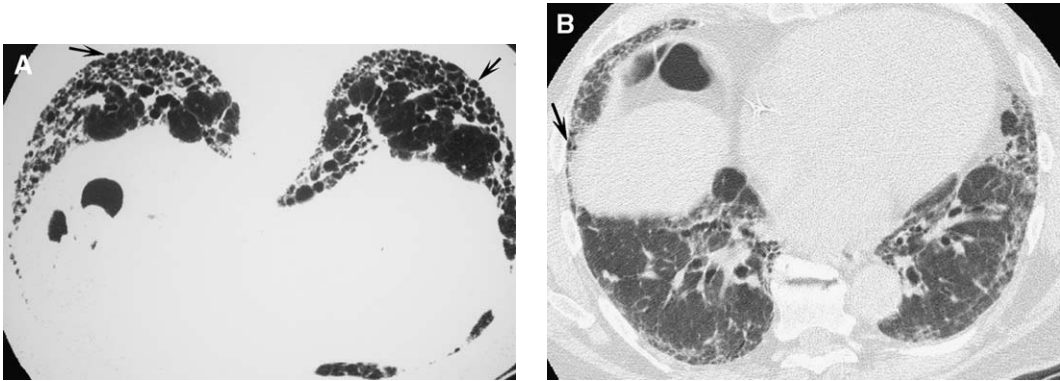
HRCT demonstration of honeycomb lung in patients with idiopathic pulmonary fibrosis—usual interstitial pneumonia (UIP). (A) Axial HRCT image through the lung bases shows multiple cystic structures in the subpleural regions of lung (arrows), consistent with honeycomb lung. Note how the cysts stack on themselves in layers and share walls with one another. (B) Axial HRCT image through the lung bases shows subpleural reticulation (arrow), suggestive of fibrotic lung disease. Several honeycomb cysts are present within the right lower lobe, allowing the diagnosis of UIP to be suggested on the basis of imaging.
